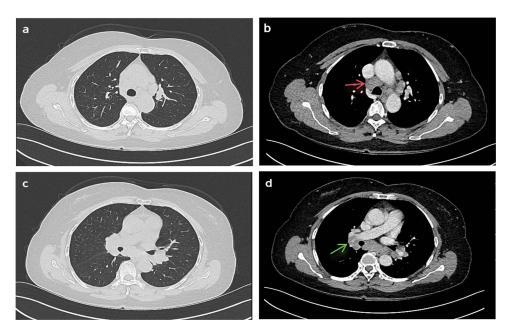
Chest CT showing enlarged (a and b) mediastinal (red arrows) and (c and d) hilar lymph nodes (green arrows) before treatment.
